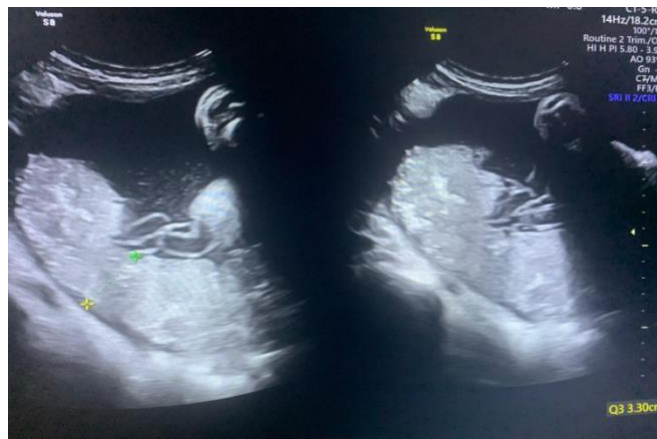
ultrasound image of 39 weeks gestational age , with maturity grade II and placental thickness (33 mm) , the EFW was 3350 gm
